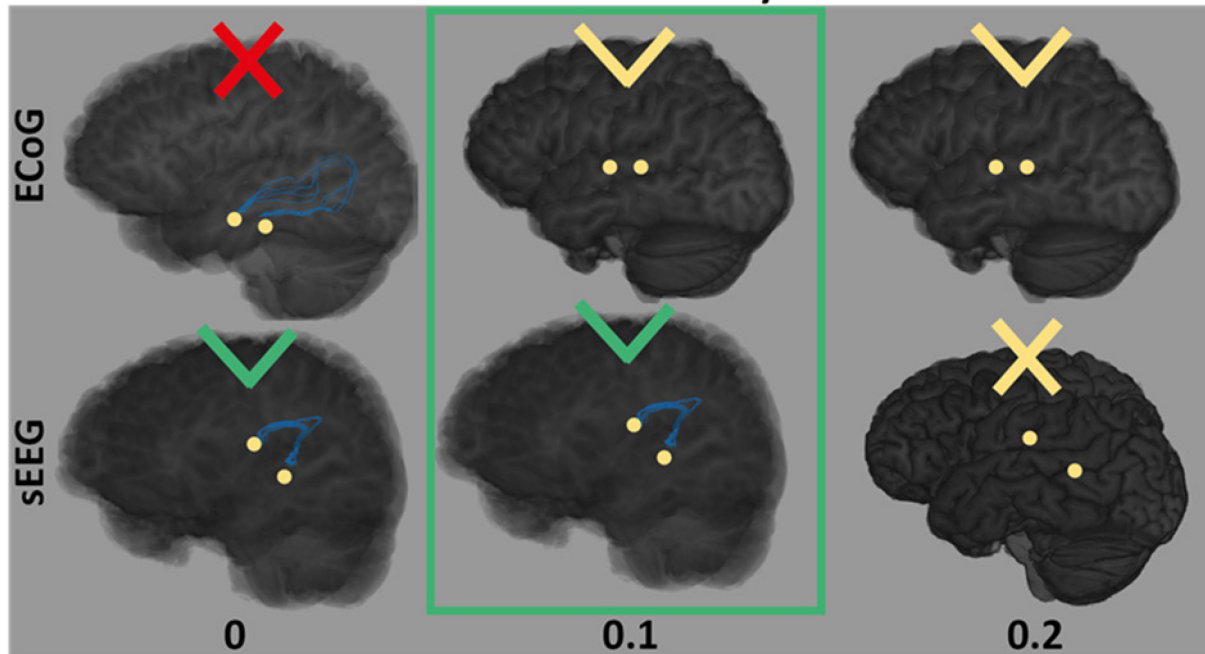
Examples of structural connections formed with varied parameter settings. The electrode contact areas (yellow) and streamlines (blue) are displayed into a 3D rendering of the de-skulled MRI-DWI. Plausible connections are indicated with a green checkmark and spurious connections with a red X. Absent connections are indicated with a yellow checkmark, when they were restricted spurious connections thus their restriction is good, and a yellow X when a plausible connections was restricted. The optimal parameter setting is encircled in green. A) With a FOD threshold of 0.1 extended spurious connections were observed. A FOD threshold of 0.2 resulted in restricted plausible connections. B) A path step size of 2 resulted in unrealistic straight streamlines in the 3D view and a path step size of 0.2 resulted in the restriction of plausible streamlines. C) With the maximum curvature angle of 70° plausible connections with highly curved, but not unrealistically curved streamlines were formed. D) A minimum streamline length of 4 mm resulted in plausible connections when closely observed in a 3D view. E) Long plausible connections with streamlines following the arcuate fasciculus required a maximum streamline length of 400 mm. F) A streamline density threshold of 0 resulted in spurious connections and a streamline density of 0.2 resulted in the restriction of plausible connections.
